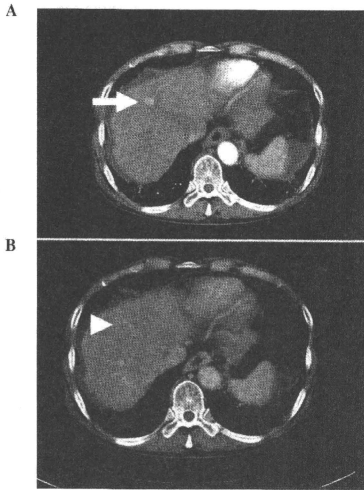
A nodule diagnosed as a typical hepatocellular carcinoma by dynamic computed tomography. (A) The nodule was enhanced in the arterial phase (arrow) and (B) revealed as a defect in the late phase (arrowhead).
